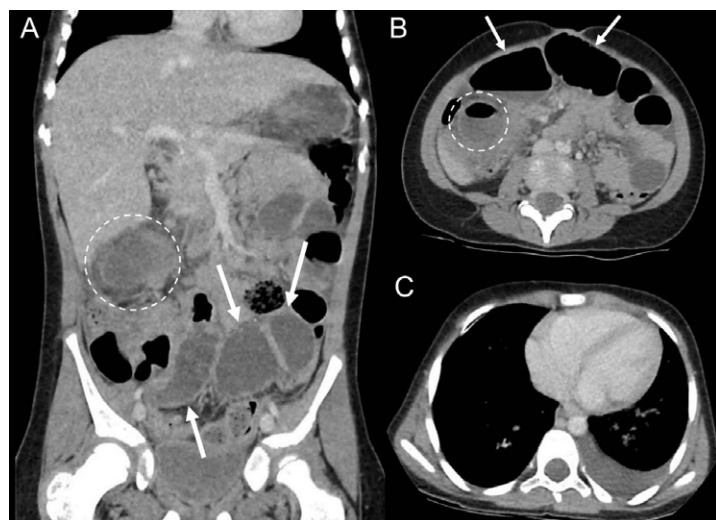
Contrast-enhanced computed tomography scan showing small bowel obstruction (arrows) and signs of small bowel suffering (dotted circle) on coronal (A) and axial (B) sections. Moderate left pleural effusion on axial section (C)
